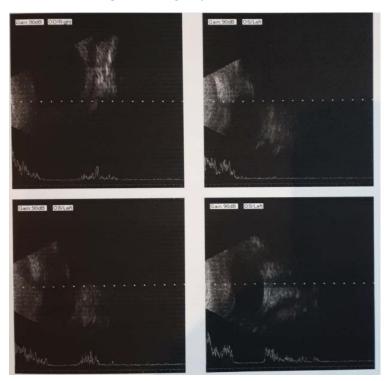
Left eye ultrasound.
